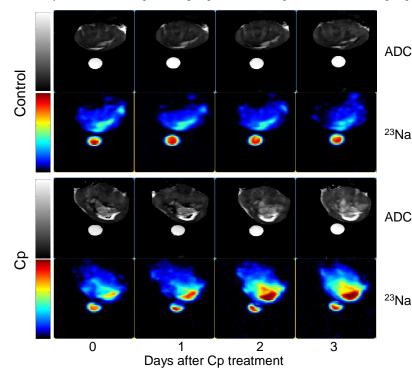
Water ADC maps and ²³Na MR images of representative control and Cp-treated RIF-1 tumors. Water ADC and ²³Na signal intensity increased with time after Cp treatment. A vial filled with a 154 mM NaCl solution was placed near the tumor as a reference.
